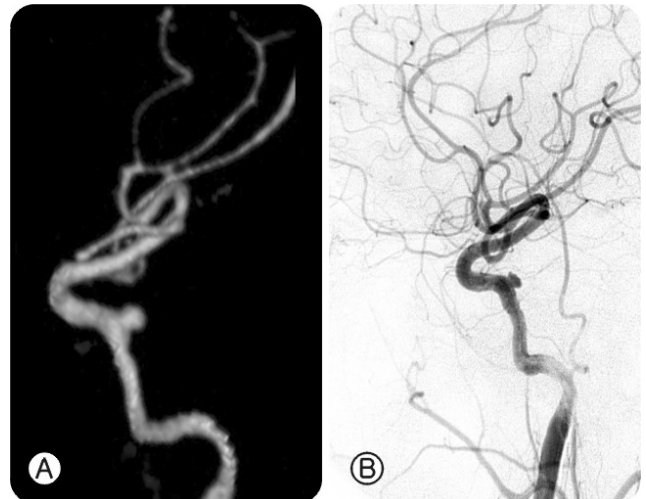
A: Three-dimensional computed tomography angiography shows aneurysm at C4/5 junction of right cavernous carotid artery and no draining vein. B: Follow up, right internal carotid artery angiogram shows the aneurysmal sac at the C4/5 junction with no opacification of cavernous sinus and draining vein.
